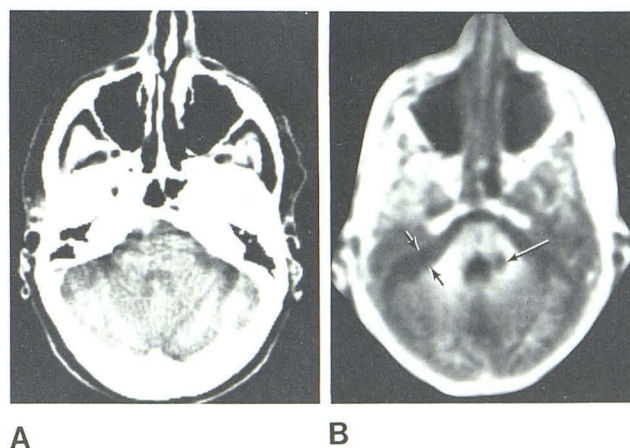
Brainstem infarction and cerebellar atrophy. A, CT. B, IR_{1400/400}. Area of infarction appears dark (long arrow). Significant CSF seen between petrous bone and anterior margin of cerebellum possibly related to cerebellar hemisphere atrophy (short arrows).
